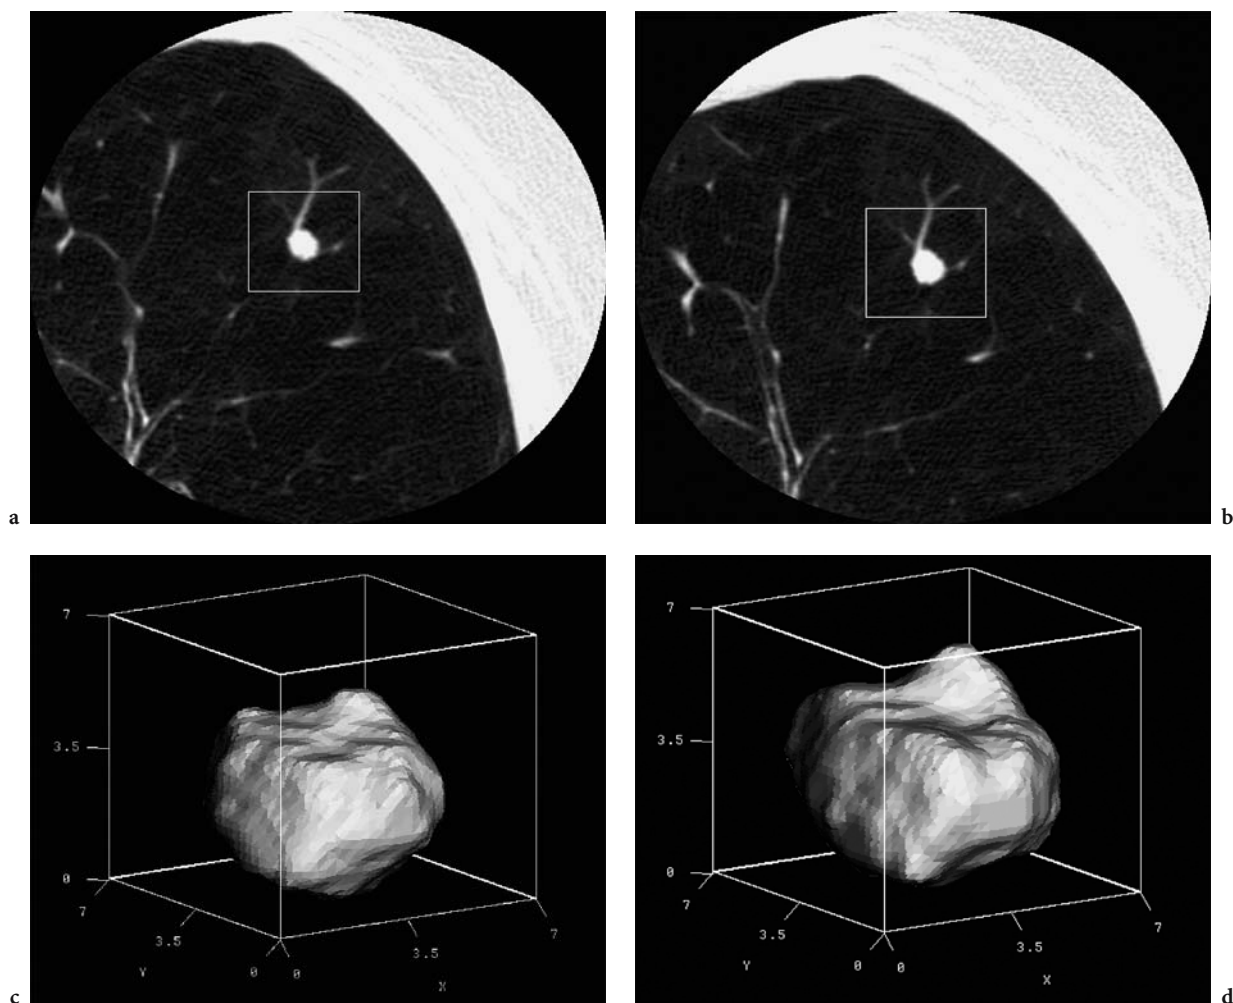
(a) High resolution CT image of a small nodule. (b) High resolution CT image of the nodule obtained at a later time. (c, d) Comparison of the 3-D renderings of the nodules respectively. Based on the time between scans and the change in volume, an estimate of the nodule volume doubling time can be easily performed
